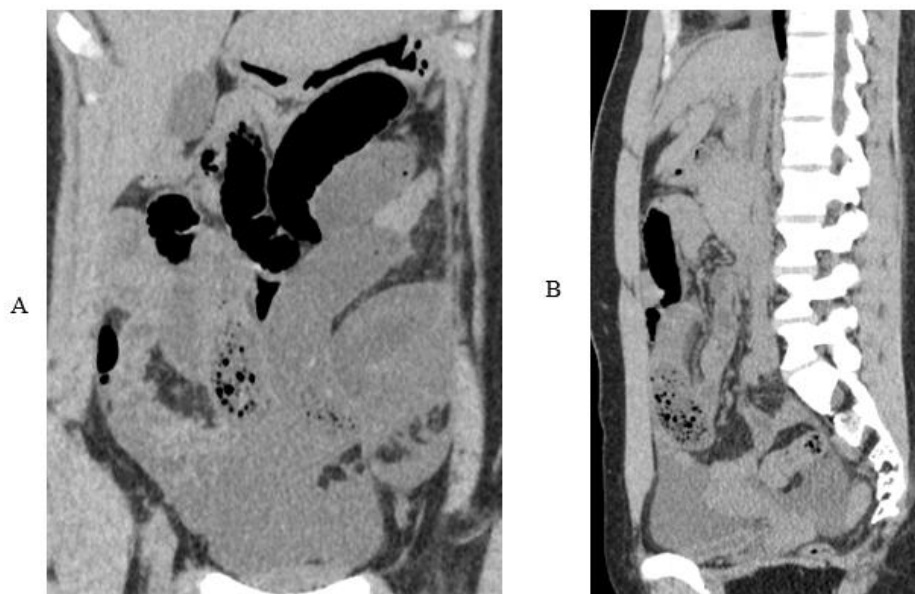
Coronal (A) and sagittal (B) CT images depict small bowel with thickened-mural associated with feces sign.
